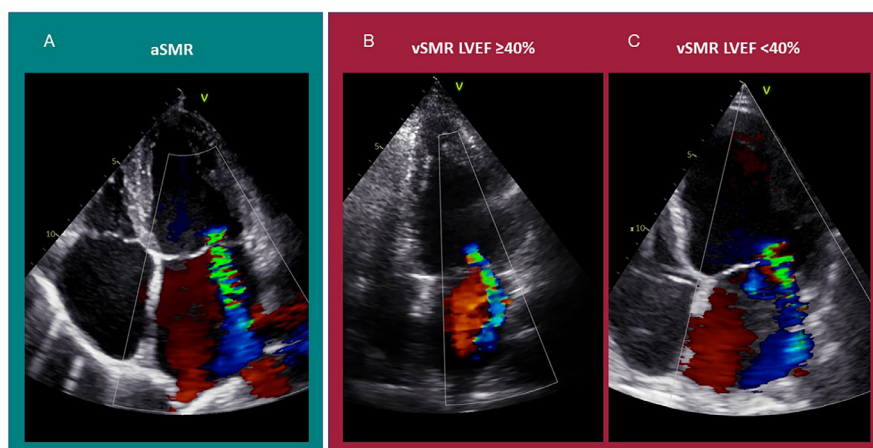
Examples of the underlying aetiology in patients with moderate SMR. (A) Echocardiographic image from a patient with moderate aSMR with leaflet malcoaptation due to annular dilatation, with normal LVEF (ie, $\geq 50\%$), no regional wall motion abnormalities and with normal LV dimensions. (B) Echocardiographic image of a patient with moderate vSMR and LVEF $\geq 40\%$ with leaflet malcoaptation due to restriction of the posterior mitral valve leaflet in the presence of wall motion abnormalities after inferoposterior myocardial infarction. (C) Echocardiographic image of a patient with moderate vSMR and LVEF $< 40\%$ with leaflet malcoaptation due to tethering in the presence of LV dysfunction and dilatation in dilated cardiomyopathy. aSMR, atrial SMR; LVEF, left ventricle ejection fraction; SMR, secondary mitral regurgitation; vSMR, ventricular SMR.
